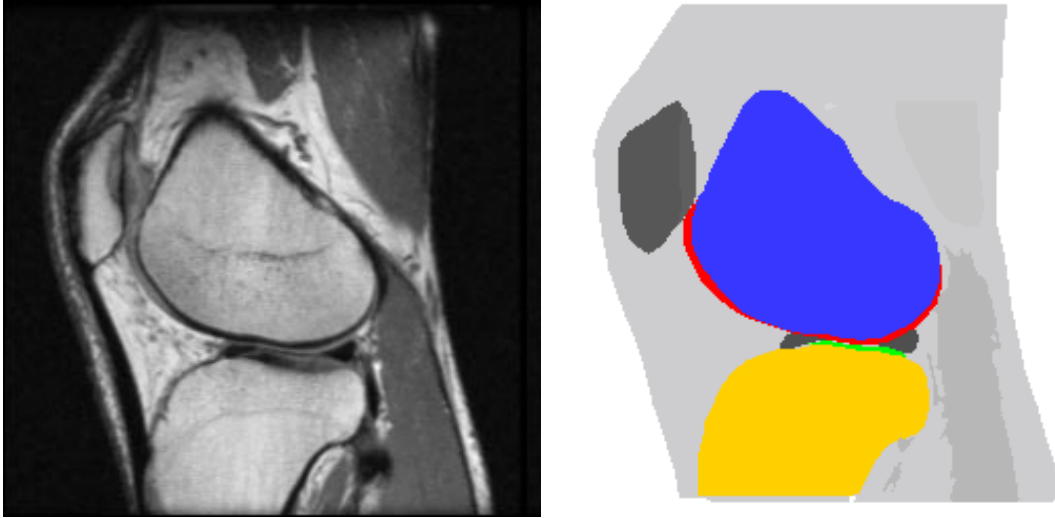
On the left is a sagittal cross-section image from a knee MRI. On the right is a segmentation of the image into four structures: the femur - the thigh bone (blue), the tibia - the shin bone (yellow), the articular femoral cartilage (red), and the tibial cartilage (green). Note the undistinguishing graylevel of the cartilage in the image on the left, and its unique geometric relationship to the bone in the image on the right.
